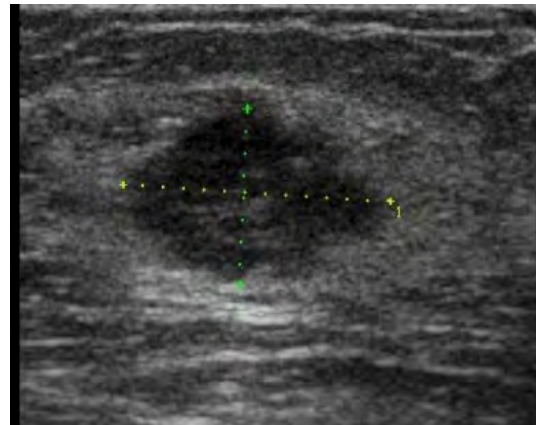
ultrasound image of the mass lesion seen on MX in fig 1 shows an hypoechoic mass with an irregular shape, and microlobulated, angular margins.
